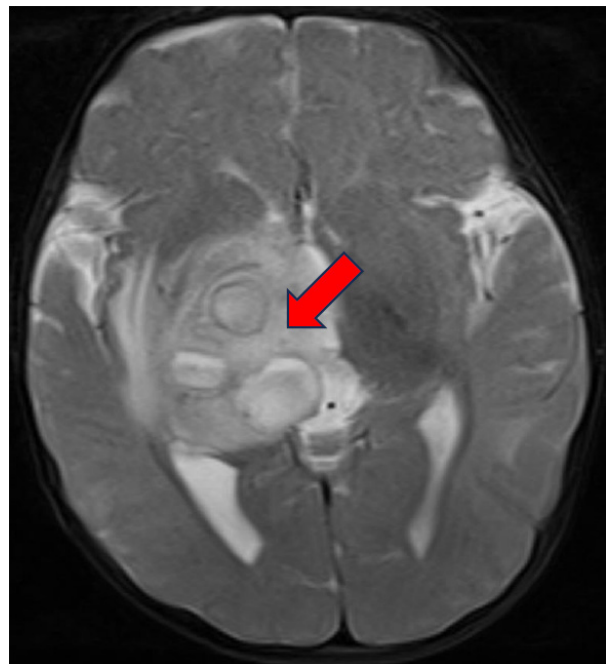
Magnetic resonance imaging of P5 showing a brain abscess.
